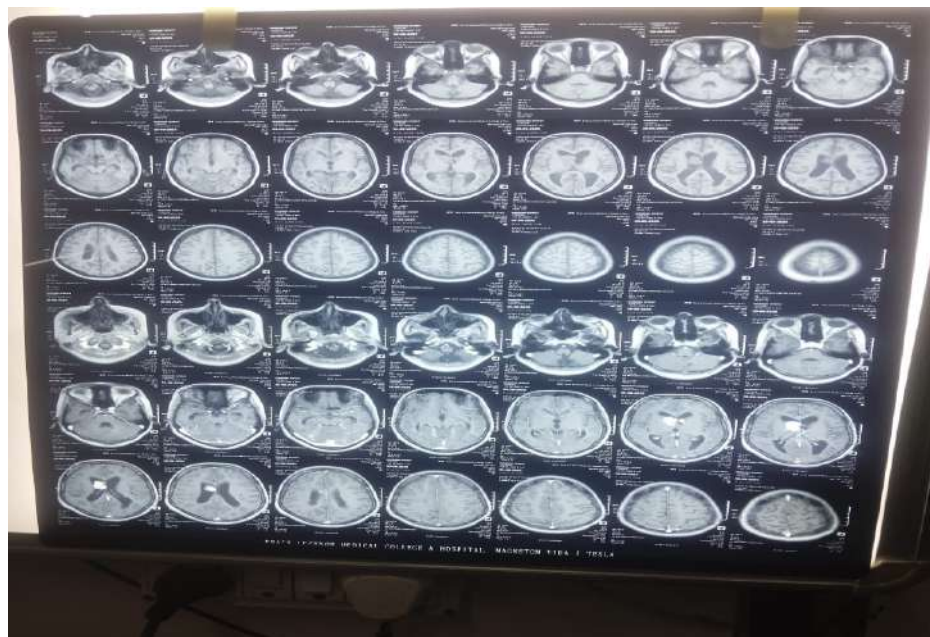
MRI brain of Case 2 showing cortical tubers and subependymal nodules.
